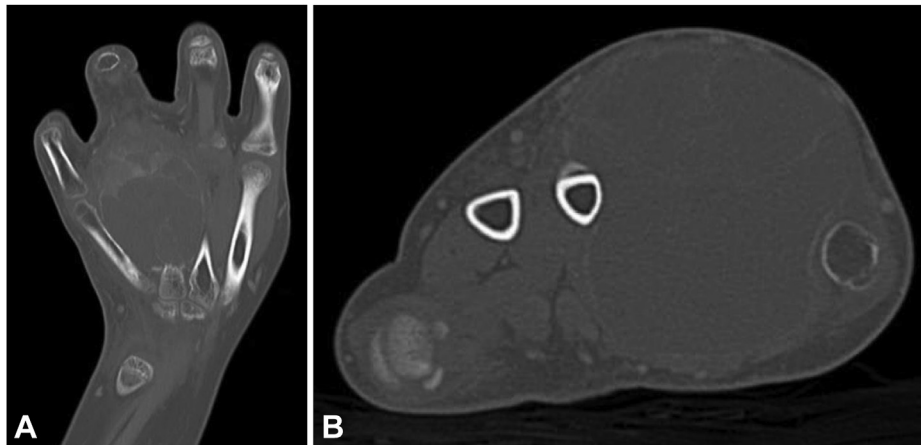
Coronal and axial cuts of a computed tomography scan demonstrating an expansile lesion encompassing the entirety of the fourth metacarpal with near-complete erosion of the cortical margins.
